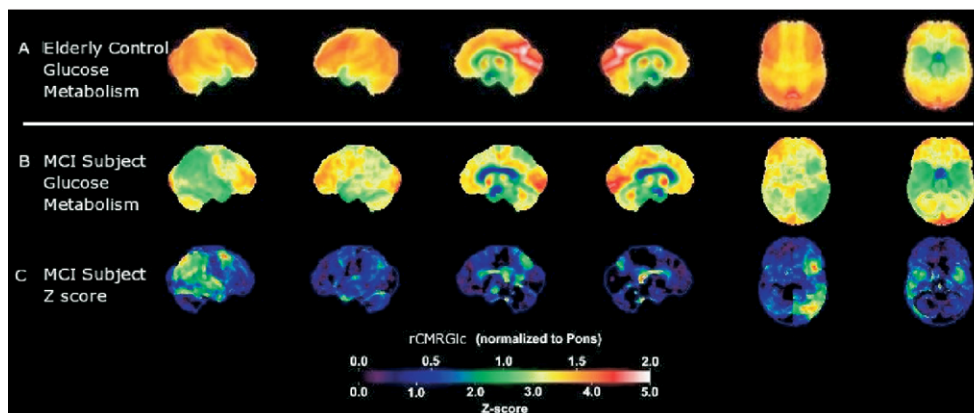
FDG-PET scan in a subject with MCI who shows an AD pattern of glucose hypometabolism. Results are displayed as Neurostat SSP images as described in Fig. 1. This scan (rows B and C) is from a subject with MCI enrolled in the ADNI study. The statistical map (row C) is derived from calculating a pixel-by-pixel Z score when compared with 27 normal elderly control subjects (row A). There is hypometabolism predominantly involving the right posterior temporoparietal association cortex, with lesser changes in the posterior cingulate and frontal cortex in that hemisphere. It is interesting to note that relative sparing of the dominant left hemisphere might account for better performance on the heavily verbally weighted MMSE used to distinguish subjects with MCI from those with AD.
